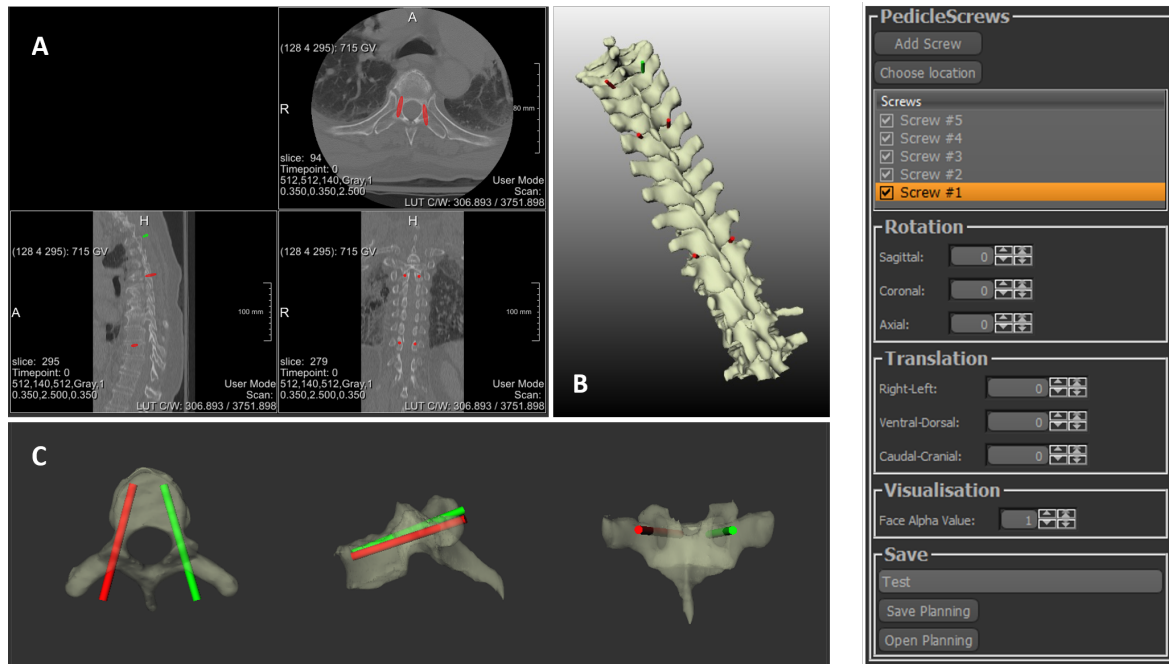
This figure consists of four images. The three images on the left show all three visualization methods. Top left (A) shows the 2D CT visualization. Top right (B) depicts the 3D method and on the bottom (C) the hybrid method is visualized. In all three the screws are represented as cylinders. The selected screw is green where all other screws are red. The right image is a image of the side panel used to manipulate the screws.
